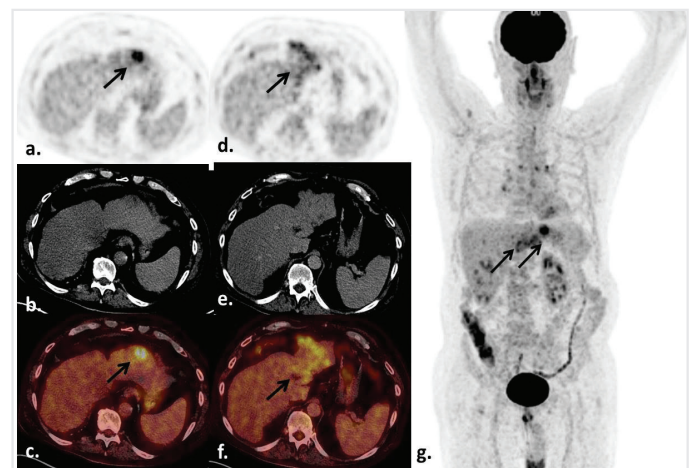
Pretreatment F-18 FDG PET/CT images of a 57-year-old male patient with hepatocellular carcinoma showed high FDG uptake in the left lobe of the liver extending along the portal vein without any distant metastasis: Axial PET (a), CT (b), fusion (c) and MIP images (d) (arrows)
